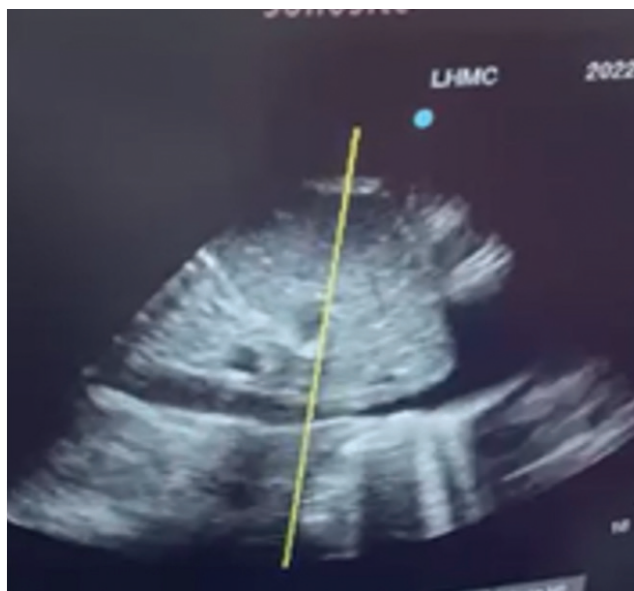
Parasternal long axis view (PLAX)
